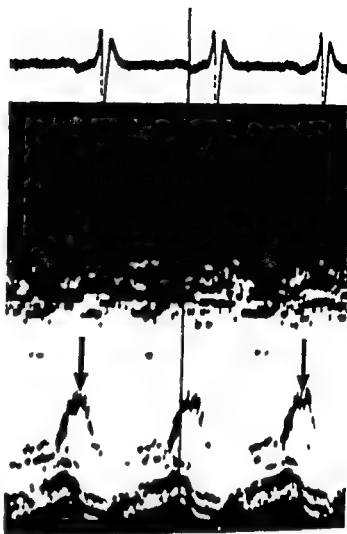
The mitral valve echocardiogram of an incompetent Björk valve is shown. The arrows indicate fine fluttering of the anterior leaflet of the mitral valve.
